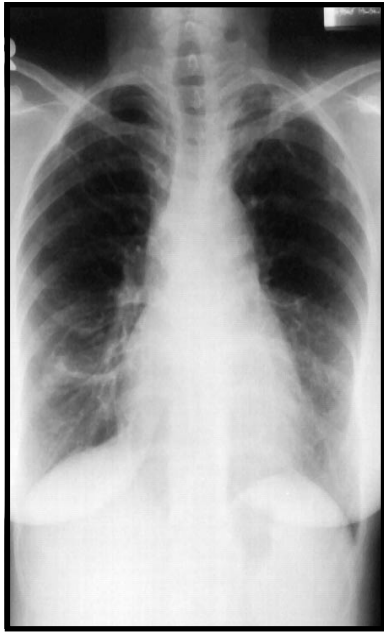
Patient 1 - Chest radiograph showed complete resolution of lung opacities after corticosteroids therapy.
